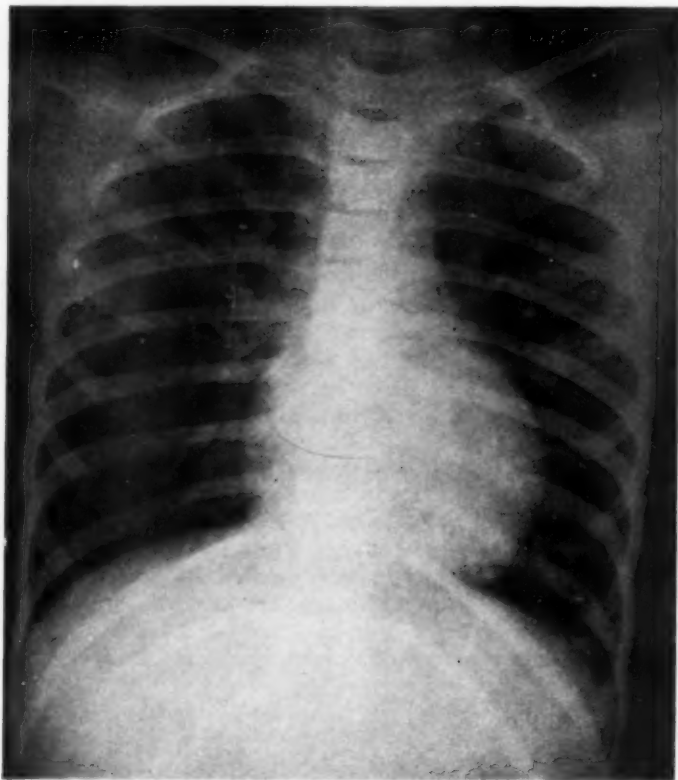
Roentgenogram of heart before operation.
